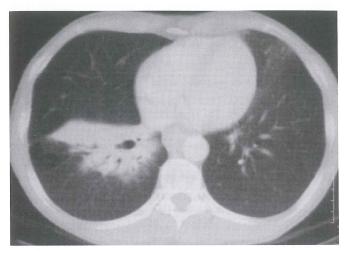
Localized consolidation area, which was stable after five years, is seen on CT scan of thorax.
